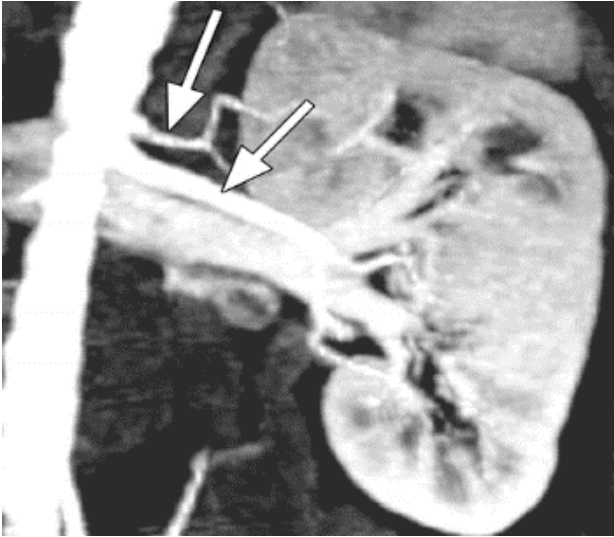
CT angiogram of a 40-year-old male with a single supernumerary of the upper polar artery
